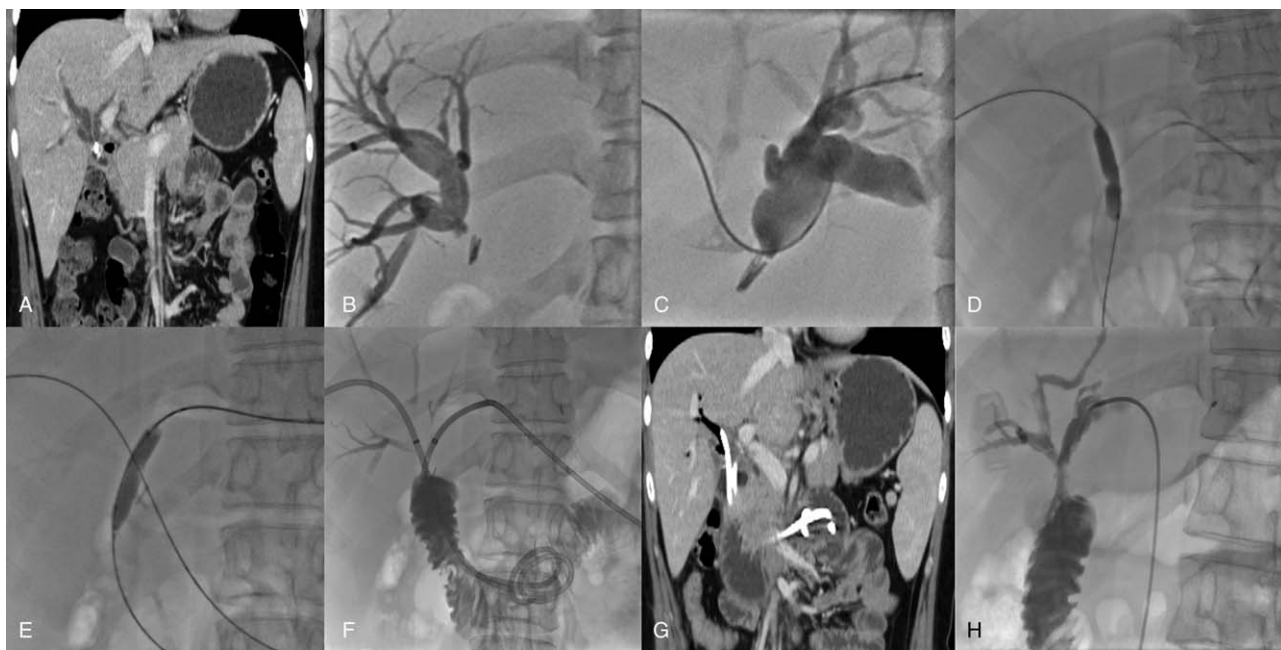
A case of benign anastomotic stricture treated with repeated balloon dilatation with long-term biliary drainage. (A–C) This figure depicts a 26-year-old woman who underwent cholecystectomy, cholangiolithotomy, and hepaticojunostomy for cholecystocholedo-cholithiasis 6 months previously. Four months following this procedure she presented with abdominal distension and fever. CT and PTC revealed a benign biliary-enteric anastomosis stricture. (D–E) Balloon dilations were performed in the right and left bile ducts. (F) Post balloon dilatation, 2 8.5F internal and external biliary drainage tubes were implanted at each side. (G) At 6 months postoperatively, CT showed no obvious dilatation of the intrahepatic bile ducts. (H) Repeat biliary angiography showed that the narrowing was cleared, following which the drainage tubes were removed. CT=computed tomography; PTC=percutaneous transhepatic cholangiography.
